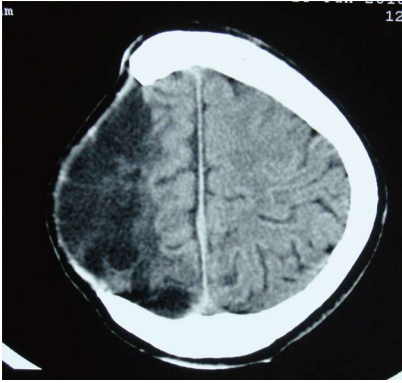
Computed tomography scan showing right cranial defect.
